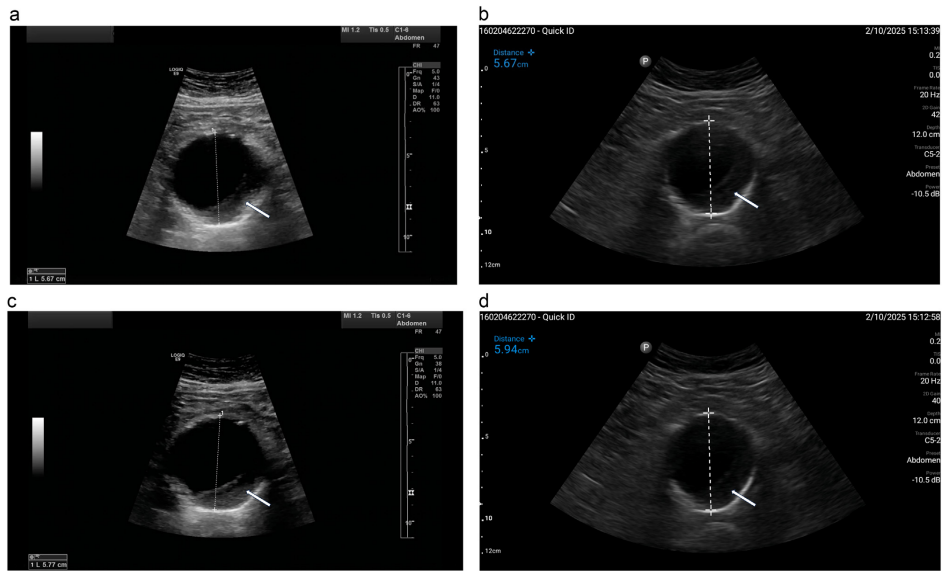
All measurements were obtained using the leading-edge-to-leading-edge technique in the transverse plane. Thrombus is indicated by a white arrow. Panels (a) and (b) show identical measurements of an abdominal aortic aneurysm (AAA) using standard ultrasound and handheld POCUS, respectively. Panels (c) and (d) show measurements that differ between the two modalities. Photo: A Mosonyi.
